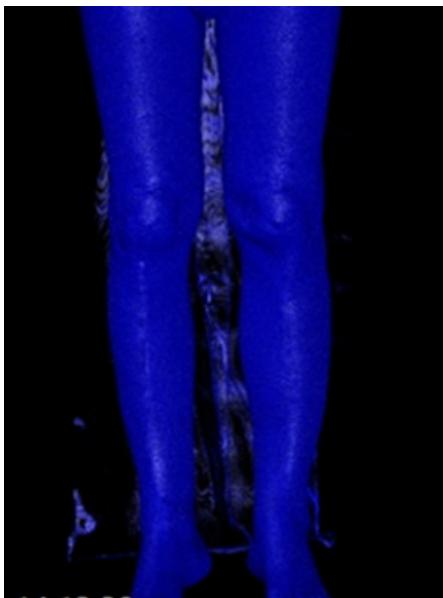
coronal CT scan of the lower limbs with X-ray-like reconstruction.
